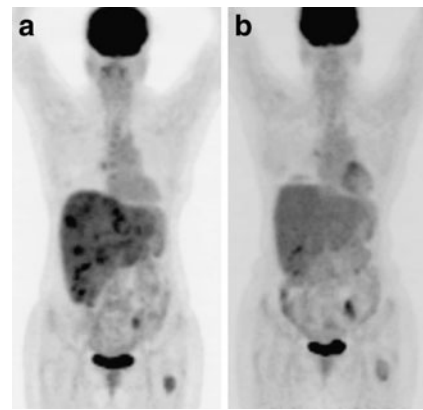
a FDG PET (coronal view) showing diffuse liver metastases and two bone lesions (left pelvis and left femur) in a female patient with previously resected right ACC. b FDG PET (coronal view) showing a good objective response in the liver after 6 months of treatment with mitotane. Mitotane plasma levels above 14 mg/L were reached 4 months earlier
